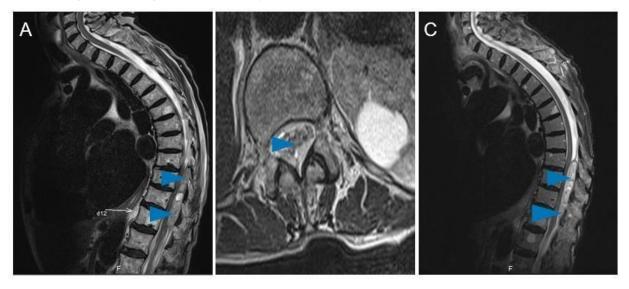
(A,B,C): Mid- sagittal (A,C) and axial (B) MRI T2 sequences demonstrating the dorsal hematoma spanning T9-T12 with multilevel cord compression. Without apparent myelopathy.
